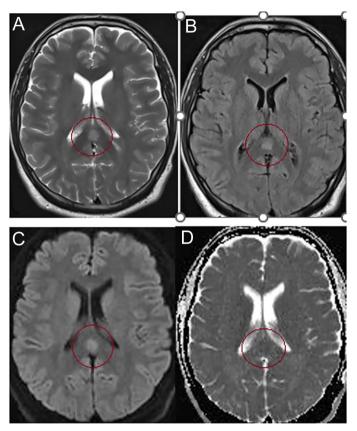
T2-weighted (A, circle) and fluid-attenuated inversion recovery (B, circle) axial images reveal a hyperintense round lesion in the splenium of the corpus callosum. The lesion shows restricted diffusion with a high signal on diffusion-weighted imaging (C, circle) and a low signal on the apparent diffusion coefficient (D, circle).
